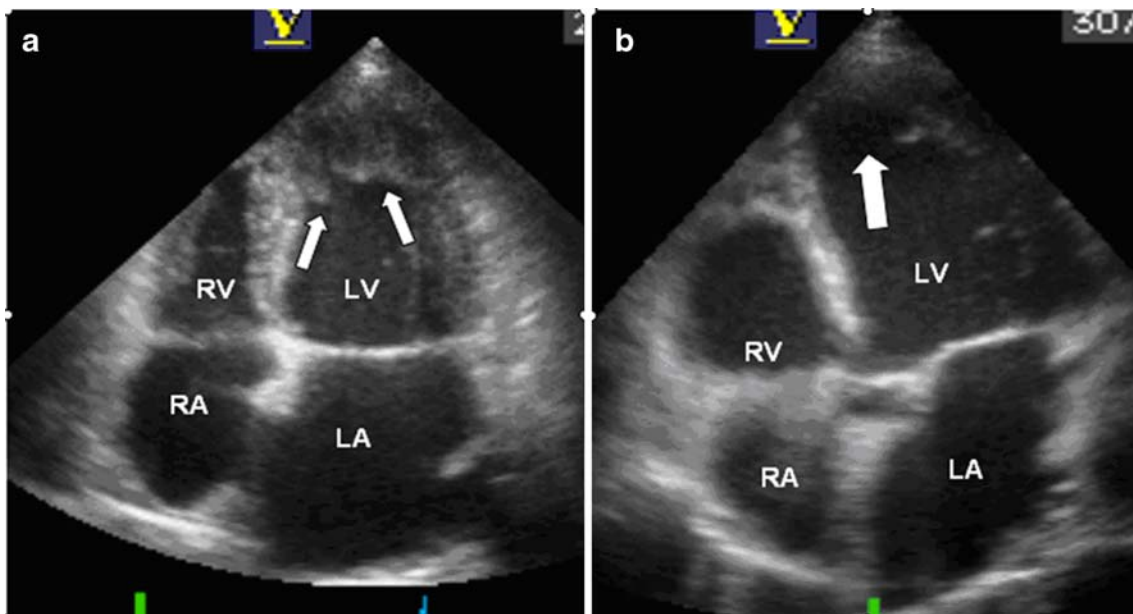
Control echocardiographic examination reveals regression in the apical obliteration of the left ventricle 3 months after treatment (a). The mass disappeared 12 months after treatment (b). (RV: right ventricle, LV: left ventricle, RA: right atrium, LA: left atrium).
